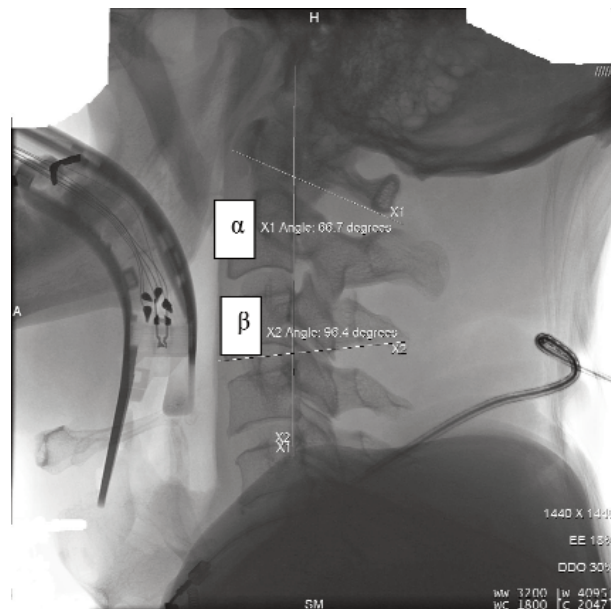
Lateral cervical spine radiograph: maximum cervical spine extension during intubation via the Airtraq®.
